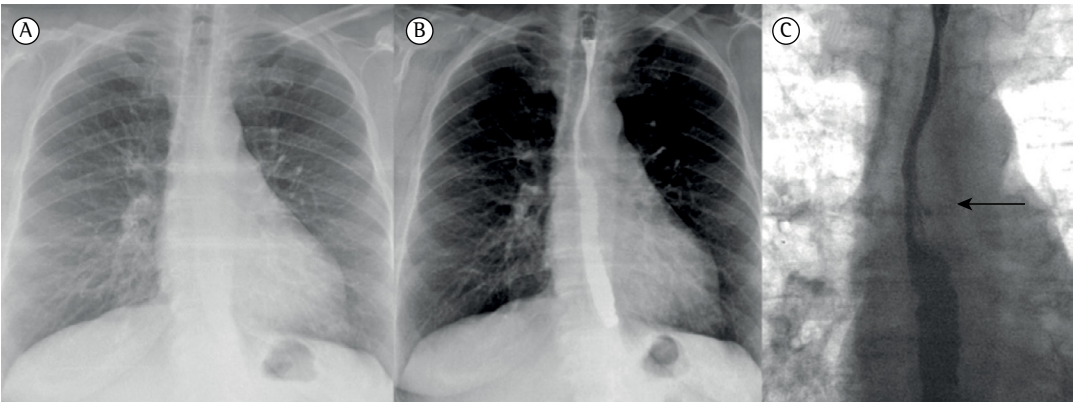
Chest X-rays of a 65-year-old man with a 4-month history of chronic cough. In A, a posteroanterior chest X-ray showing no mediastinal alterations. In B and C, posteroanterior chest X-rays taken after barium swallow and showing an irregular area of narrowing (black arrows) that was subsequently diagnosed as esophageal cancer.
